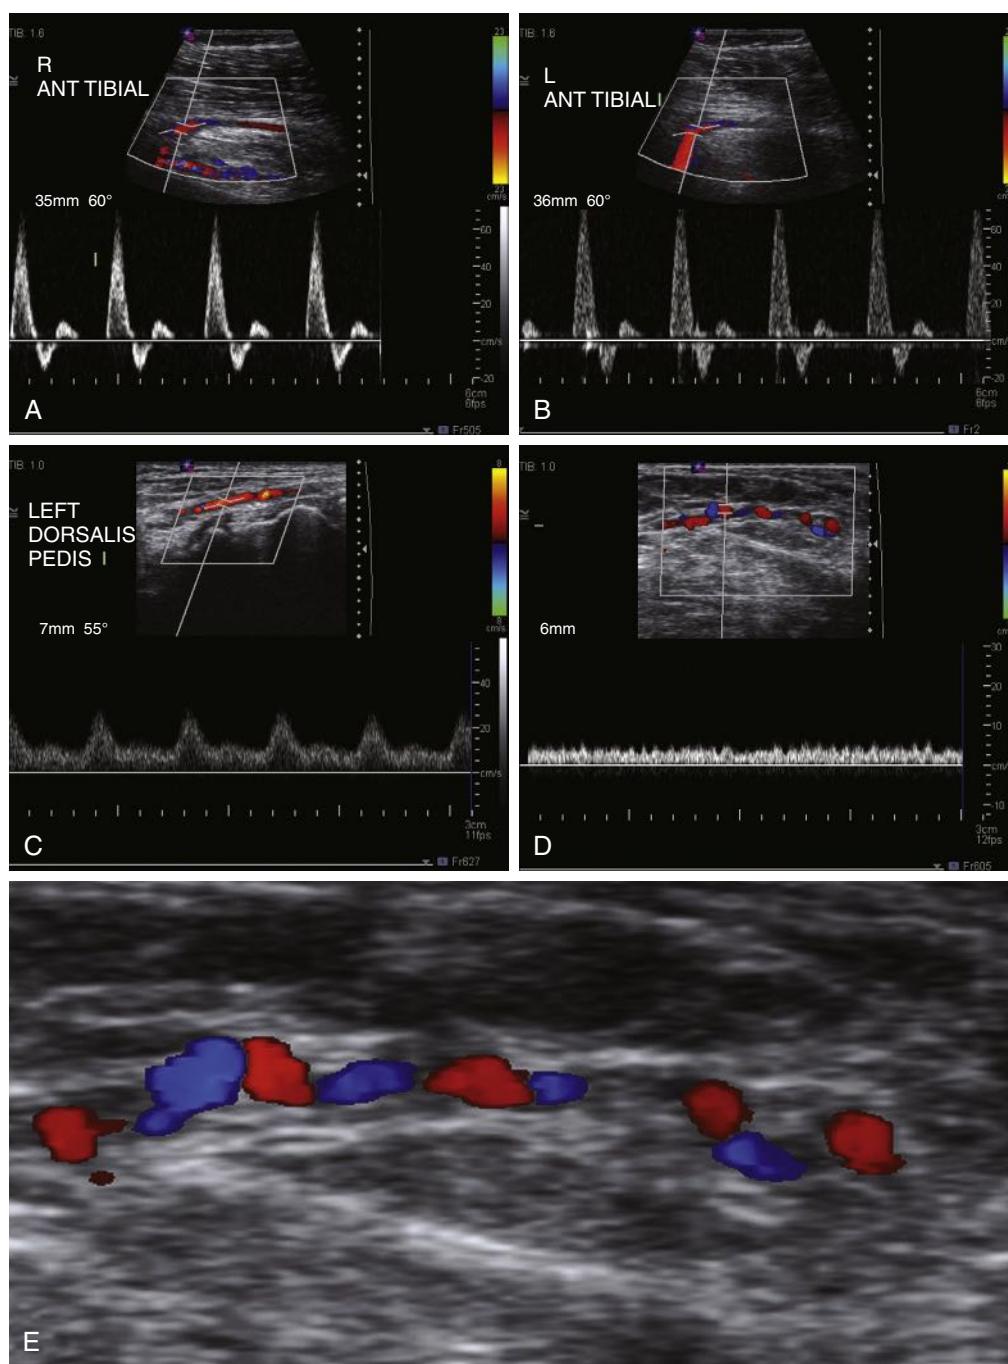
Color-flow Doppler studies demonstrating triphasic flow within the right (A) and left (B) anterior tibial arteries, monophasic flow within the left dorsalis pedis artery (C), and the “dot” sign because of continuous flow within corkscrew collaterals at the toe level (D and E).
